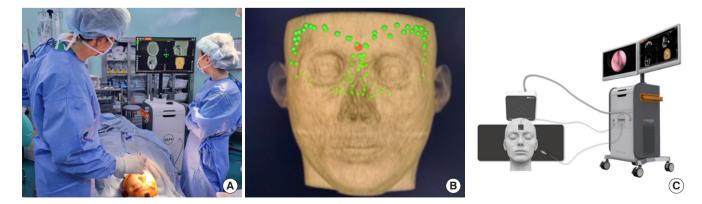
(A) The intraoperative registration of a reference point on the patient's computed tomography image is integrated into the navigation system. This system, an electromagnetic navigation system, tracks instruments by generating an electromagnetic field. It functions with a generator that produces this electromagnetic field beneath the patient's head. (B) Preparation for registration involves using the reference points (red point). (C) The Naviol navigation system (Mega Medical; photo used with permission) [9].
